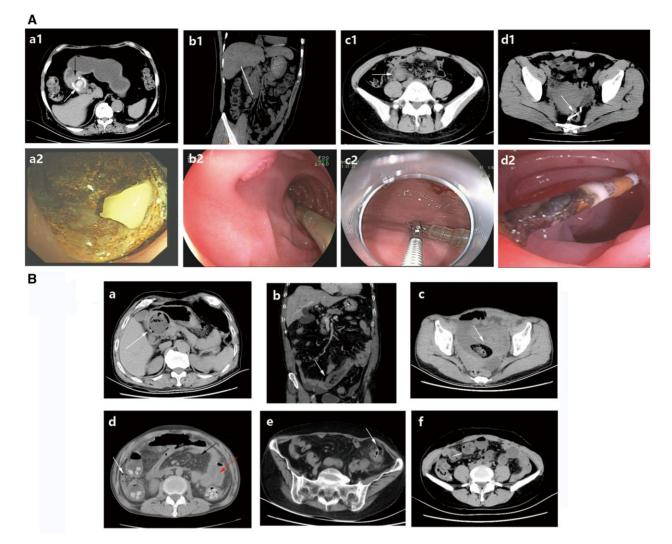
Representative images of intestinal foreign bodies. (Aa1) Representative CT image of an 81-year-old female (Patient 9) with a bezoar (white arrow) located in the duodenum that was initially misdiagnosed as gastric cancer because of gastric wall thickening (black arrow). (Aa2) Endoscopic image of Patient 9. (Ab1) Representative coronal CT image of a 35-year-old male (Patient 4) with a cartridge penetrating the duodenum and causing liver abscess. (Ab2) Endoscopic image of Patient 4. (Ac1) Representative CT image of a 32-year-old female (Patient 151) with a cartridge (white arrow) lodged in the duodenum causing duodenal prolapse. (Ac2) The cartridge was removed from Patient 151 by foreign body forceps. (Ad1) Representative CT image of a 46-year-old female (Patient 134) with an intrauterine contraceptive device (white arrow) migrated to the rectum. (Ad2) Endoscopic image of Patient 134. (Ba-c) Intraluminal round or irregularly shaped bezoars and mottled gas patterns are detected in the small intestine. Wall thickening due to inflammation is observed at the obstruction site. (Bd) Perforation and obstruction of the descending colon caused by sullowing large amounts of waxberry cores. Free gas (white arrow), peritoneal inflammation (black arrow), and wall thickening (red arrow) are observed (Be) Perforation of the sigmoid colon caused by jujube pit; free gas can be observed (white arrow). (Bf) Perforation caused by duck bone.
